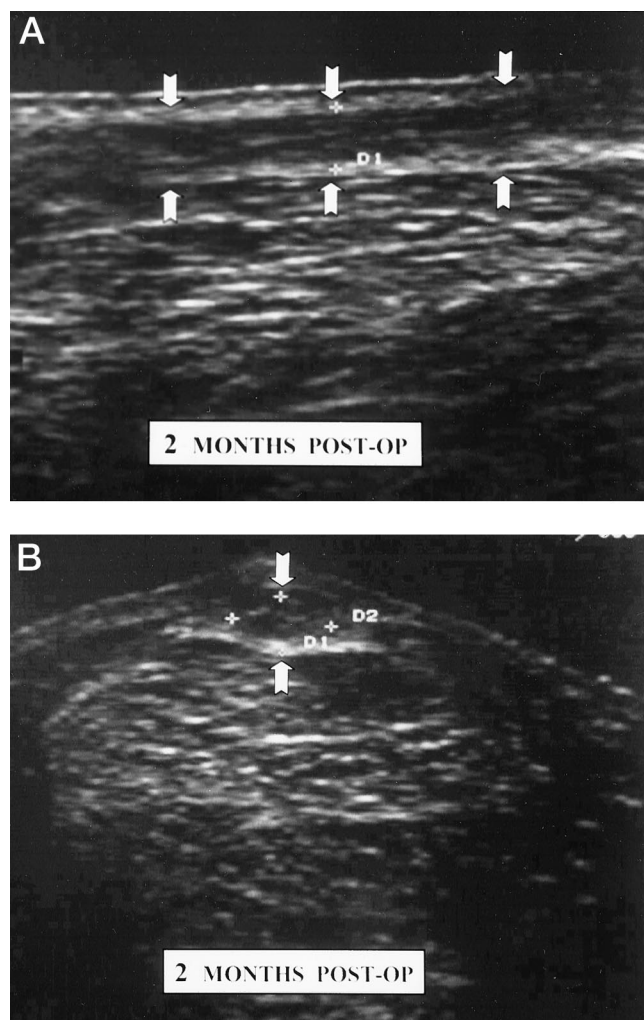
Longitudinal (A) and transverse (B) sonograms at 2 months after surgery. The area of the semitendinosus tendon is outlined by the arrows.
